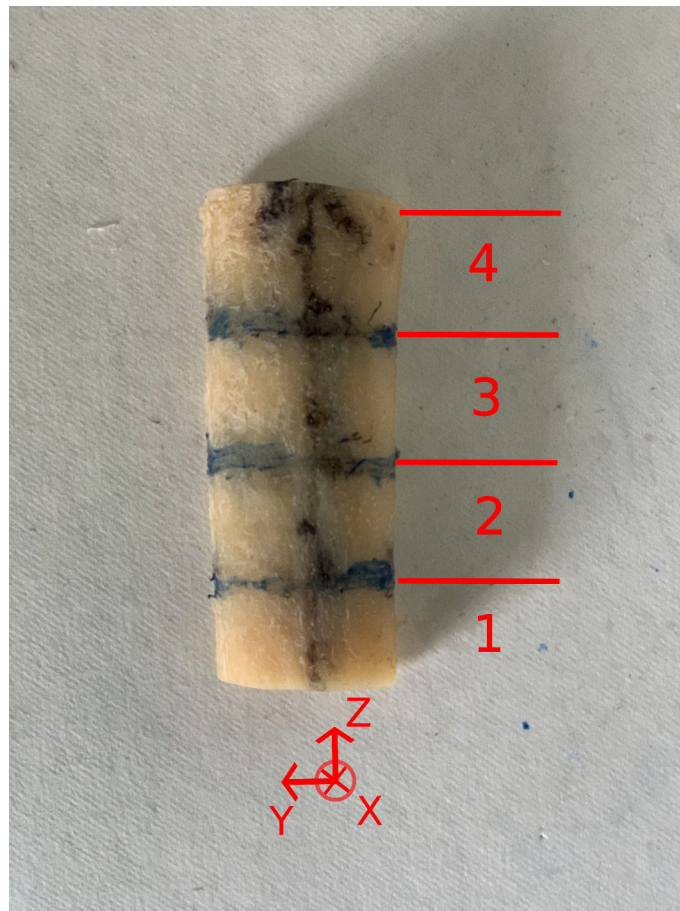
Subdivision of the samples into four subvolumes for ultrasound acquisitions. Each subvolume has a length of around 13 mm.
